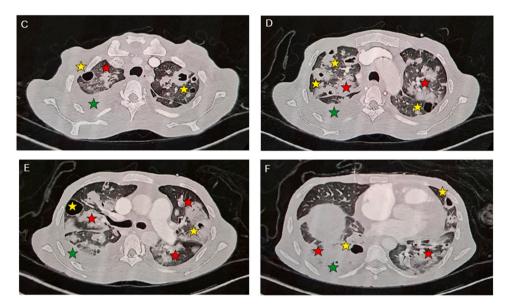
High resolution CT of the lungs progressing from apex [C] to diaphragm [F] showing a moderate right sided pleural effusion (green asterix), multiple ringenhancing cavitary lesions consistent with abscesses (yellow asterix) and patchy consolidation affected multiple lung segments bilaterally (red asterix).
